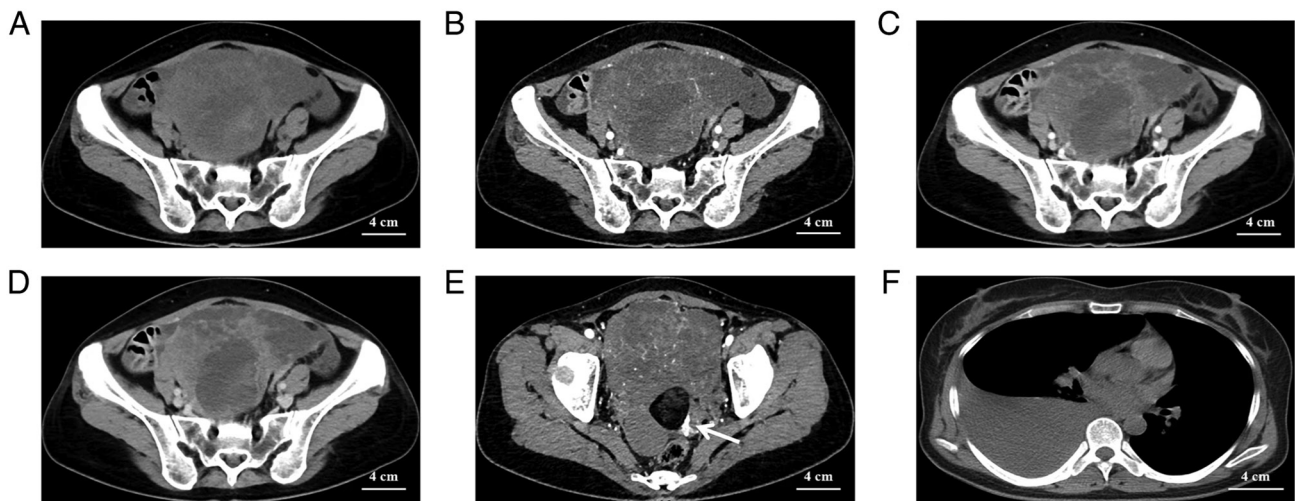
(A) CT plain scan demonstrating a massive, mixed-density mass in the pelvis of the patient, which pushed away the surrounding tissues and organs; ascites are visible around the mass. (B) CT-enhanced arterial phase image shows extensive distribution of tiny arteries in the tumor, and the parenchymal part of the tumor is mildly enhanced. (C) CT-enhanced venous phase image shows further enhancement of the parenchymal part of the tumor compared with the arterial phase. (D) CT-enhanced delayed phase image shows further intensification of the parenchymal part of the tumor. (E) The arterial phase of CT-enhanced scan shows a thick uterine artery is visible on the left posterior side of the entire mass (arrow); in addition, a small mass composed of fluid and fat is visible on the right posterior side of the entire mass; this small mass is surrounded by a substantial anterior mass and this portion does not enhance. (F) On chest CT, a substantial pleural effusion is detected on the right side of the chest cavity, whereas no fluid is detected on the left side (scale bars, 4 cm).
